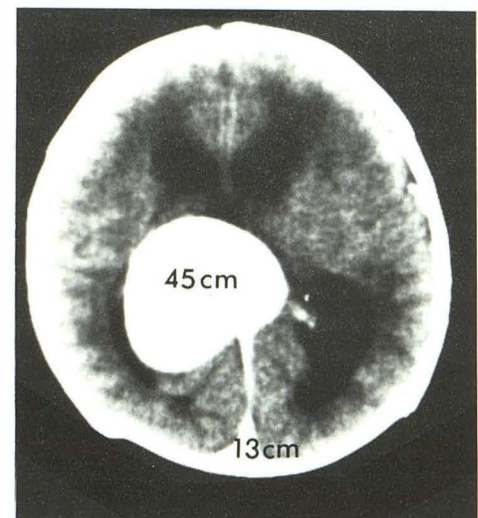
Example of grade 4 vein of Galen aneurysm/straight sinus complex. CT scan demonstrates grade 4 aneurysm/straight sinus complex with markedly enlarged vein of Galen aneurysm but a relatively normal straight sinus. Venous pressure (in cm of H₂O) is 45 cm within vein of Galen aneurysm and 13 cm within torcula. This size disparity indicates the presence of a pressure gradient across the straight sinus. None of the patients with this complex displayed evidence of brain calcification.
